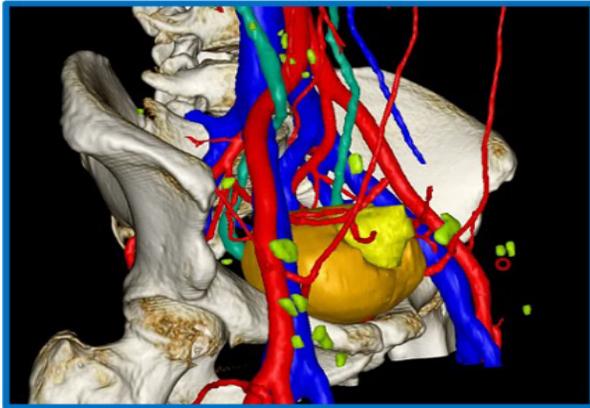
3D image reconstruction based on CT scan.
